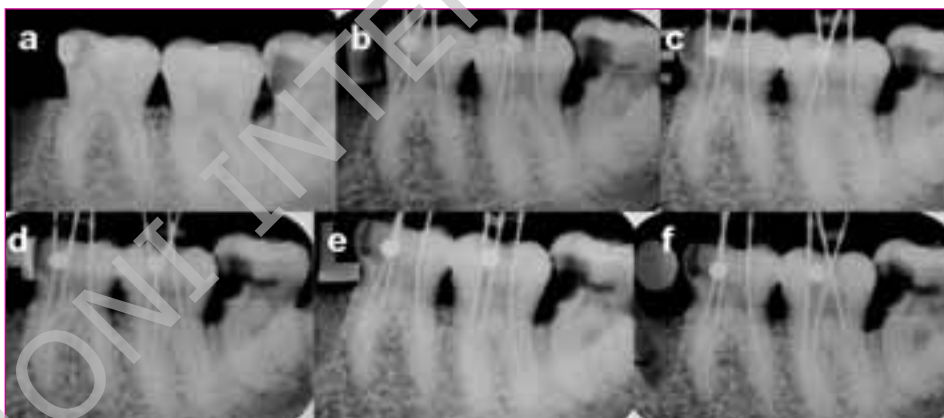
Sequence of periapical radiographs taken with E-speed films.
